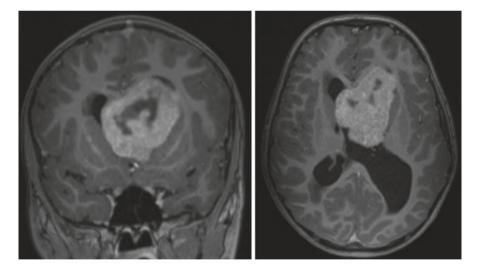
Subependymal giant cell astrocytoma in lateral ventricle: Axial and coronal T1-Gad MRI showing a left ventricular SEGA in a 7-year-old boy with tuberous sclerosis. The tumor was resected, followed by a shunt
